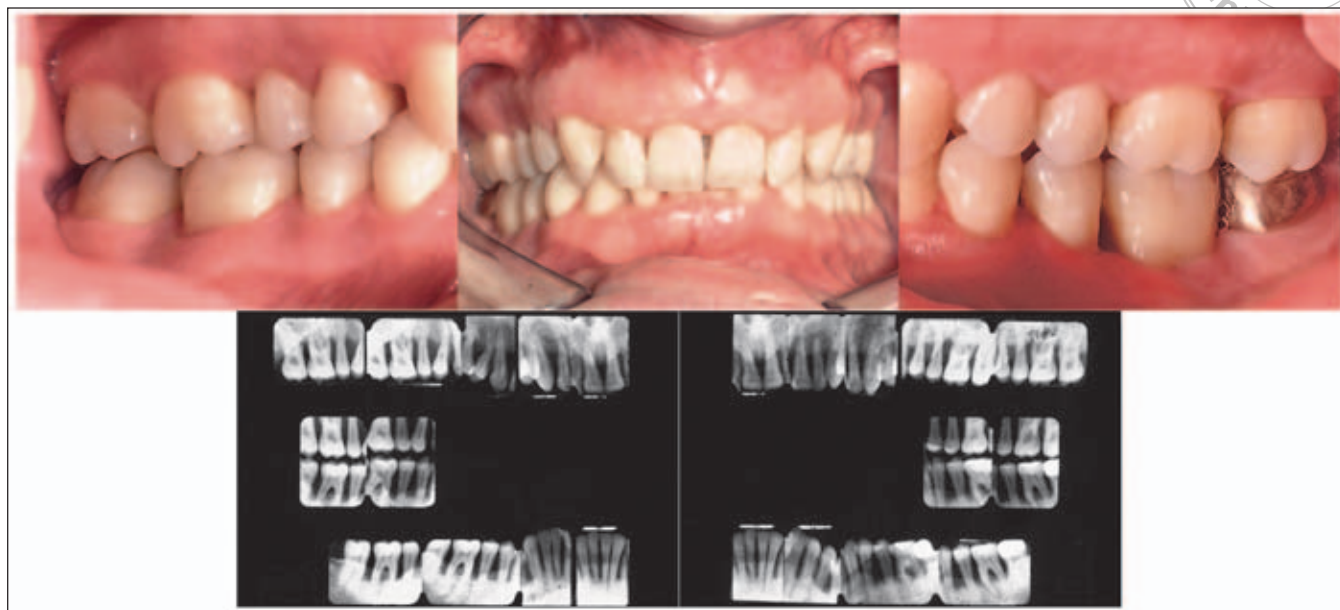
Clinical and radiographic manifestation of advanced periodontitis in a 27-year-old male. Note the relatively normal appearance of the teeth and gingival tissue and the extreme alveolar bone destruction.
